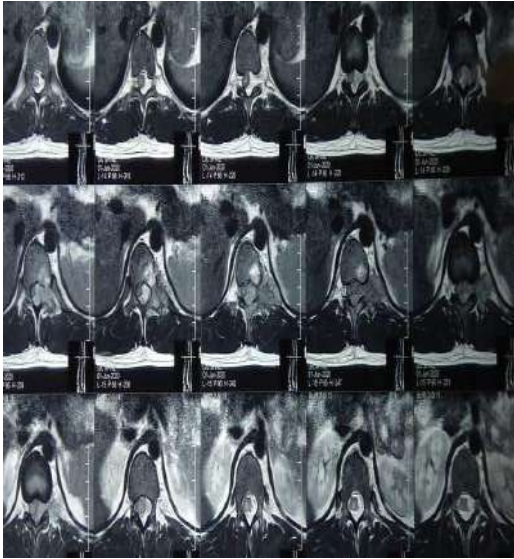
MRI D-L Spine (Axial) contrast
